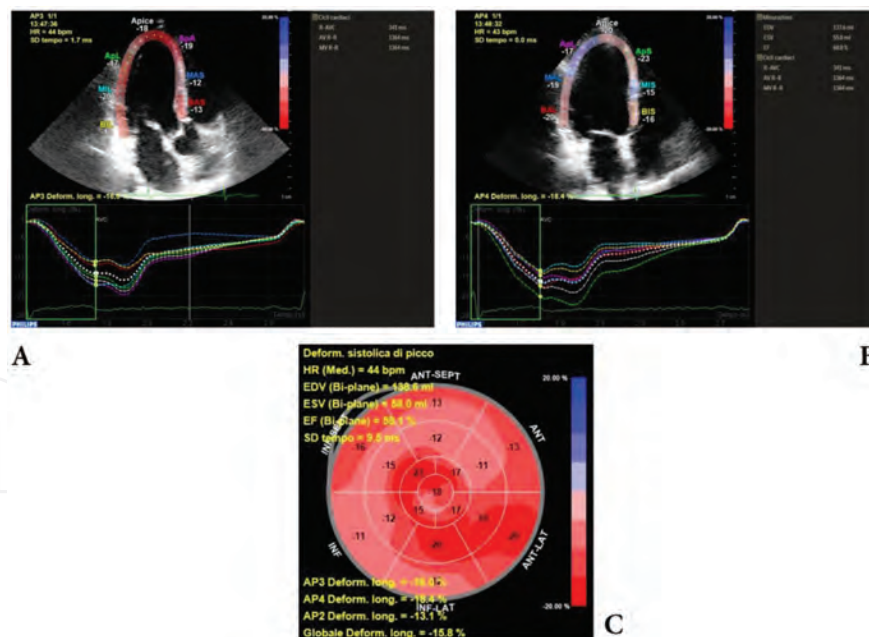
Global longitudinal strain calculation: on top showing tracking in three- (A) and four- (B) chamber view with strain curves; final bull's-eye plot (C) showing global results and superimposed regional values (dysfunctioning patient). AP2: apical two-chamber view; AP3: apical three-chamber view; AP4: apical four-chamber view; Deform. Long.: longitudinal deformation; EDV (bi-plane): end-diastolic volume (bi-plane); ESV (bi-plane): end-systolic volume (bi-plane); EF (bi-plane): ejection fraction (bi-plane); global Deform. Long. (GLS): global longitudinal strain; HR: heart rate.
